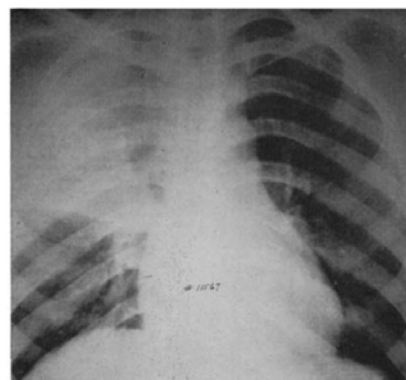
Lobar pneumococcal pneumonia; 200 roentgens to anterior right chest immediately after admission. Prompt response to irradiation, with complete recovery, temperature, pulse, and respiration showing gradual decline to normal over three-day interval.
